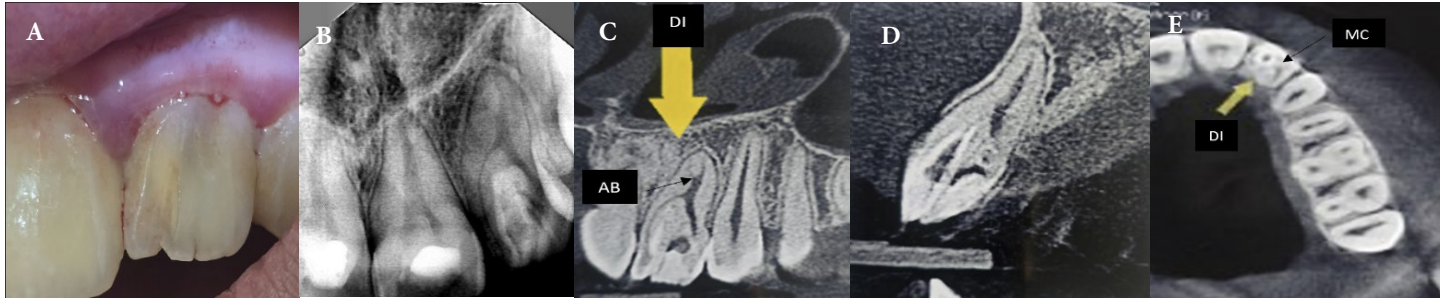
A) Preoperative clinical view of tooth #10 showing a bifid crown morphology; B) Preoperative periapical radiograph demonstrating type II dens invaginatus; C-E) CBCT images demonstrating the complex internal anatomy of the affected tooth. Arrows identify the key anatomical structures: DI indicates the dens invaginatus (invaginated canal), MC indicates the main canal, and AB indicates the apical bifurcation
